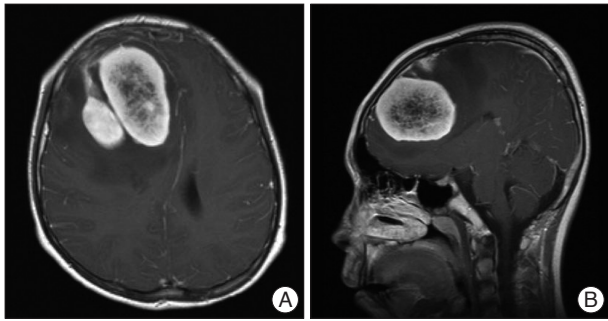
Pre-operation brain MRI. Axial (A) and sagittal (B) T1-weighted enhanced images demonstrating a multilobulated mass with peripheral enhancement, central necrosis and peritumoral edema in the right frontal lobe.
